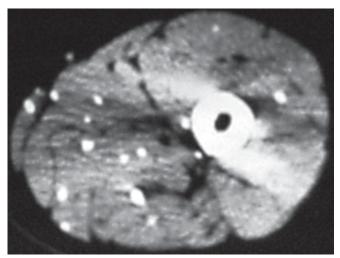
CT of thigh showing multiple calcified cysticercal lesions
